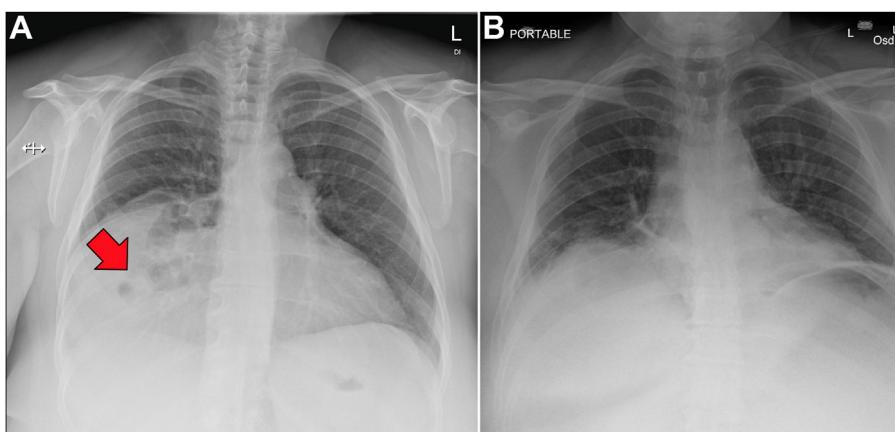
Preoperative (A) and Postoperative (B) chest X-rays from repaired complex Morgagni hernia. Red arrow depicts right-sided hernia contents containing small and large intestines.
